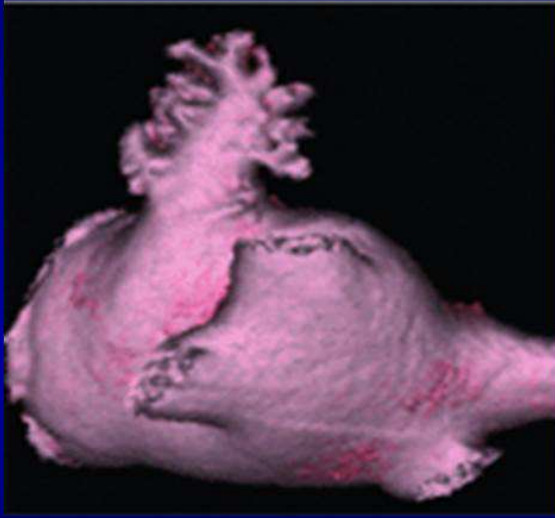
A-B CT scan and C MRI of a Windssock LAA morphology
